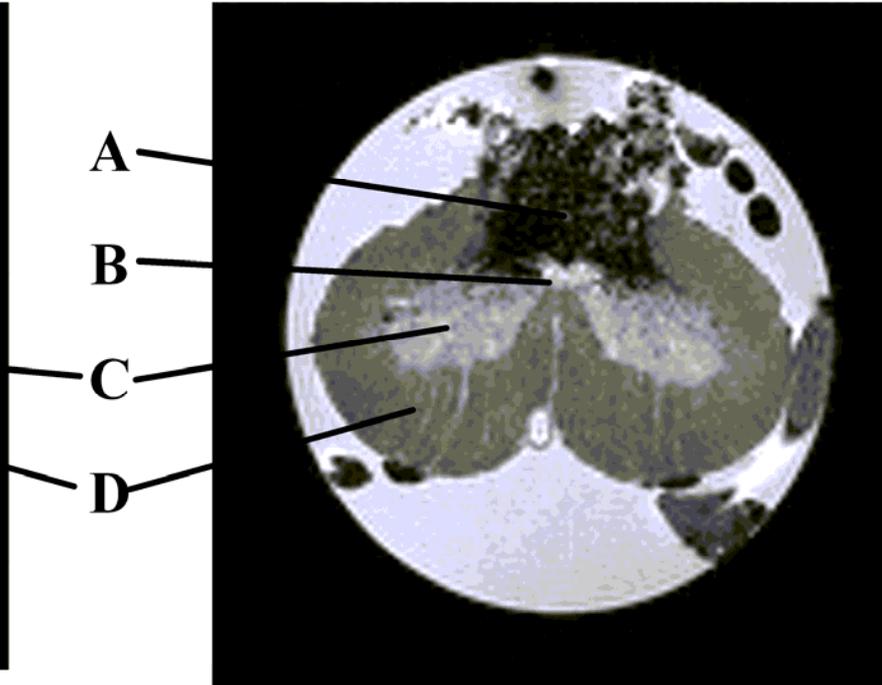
A comparison of *in vitro* MRI images in spinal cord section rostral (A) and at the level (B) of excitotoxic injury. Features of excitotoxic injury are identified as the following: A, hemorrhage; B, cavitation, C, gray matter; and D, white matter.
